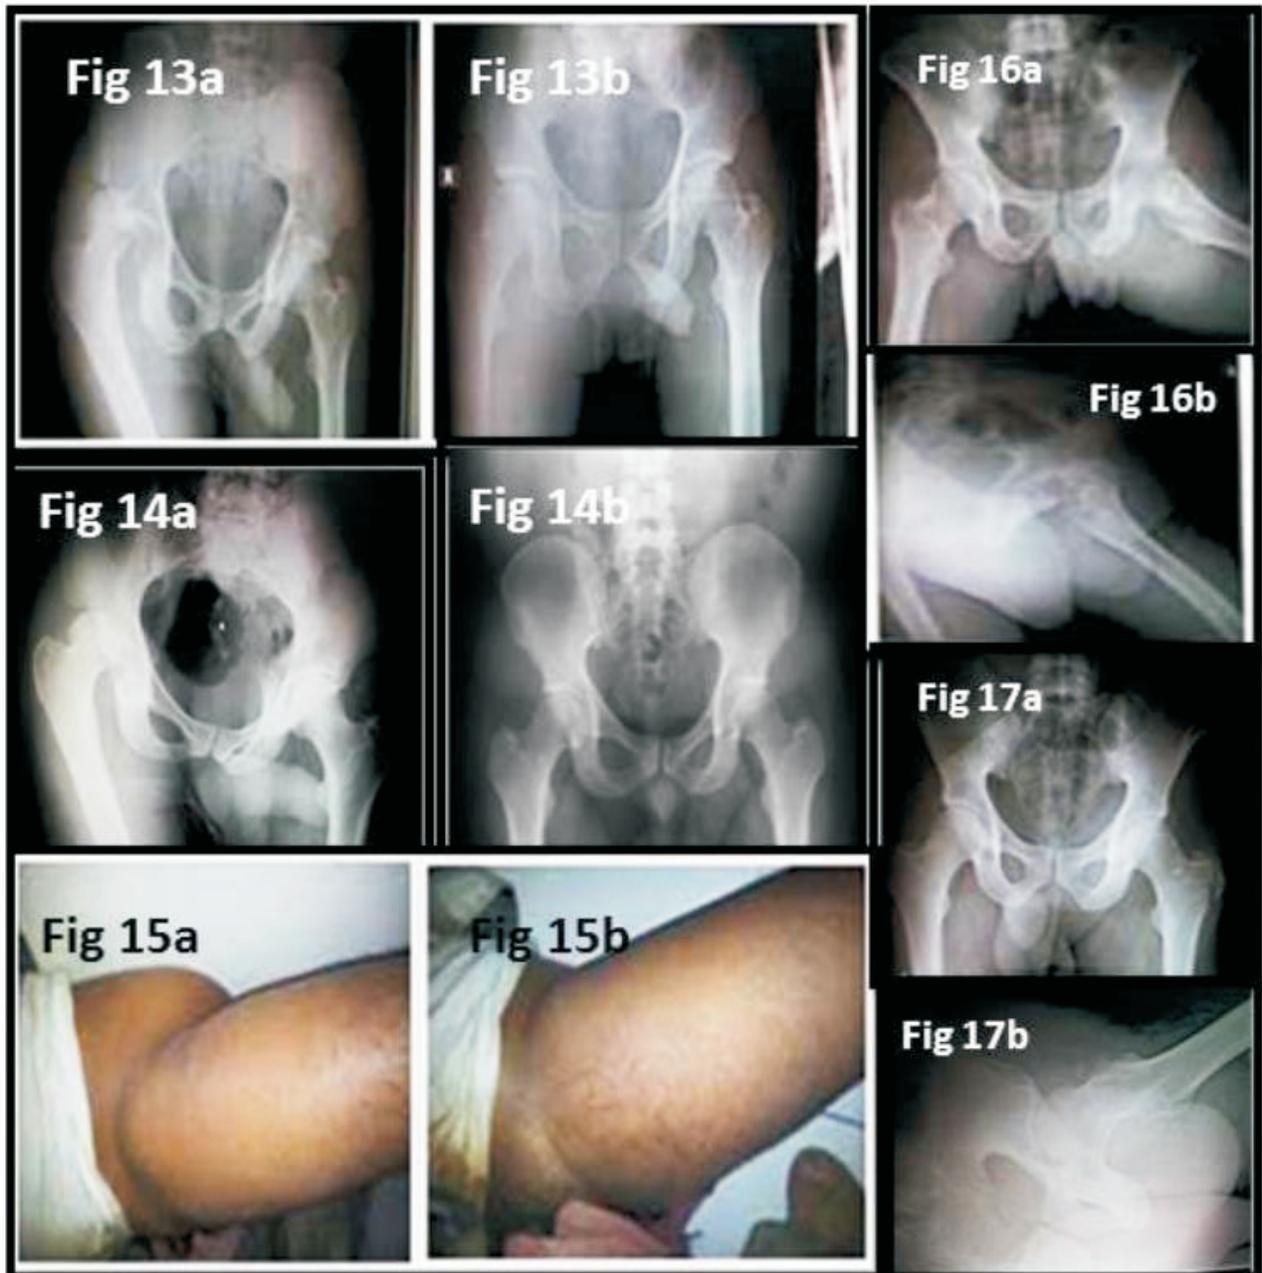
a, b : X-ray of pelvis showing posterior dislocation & post reduction
